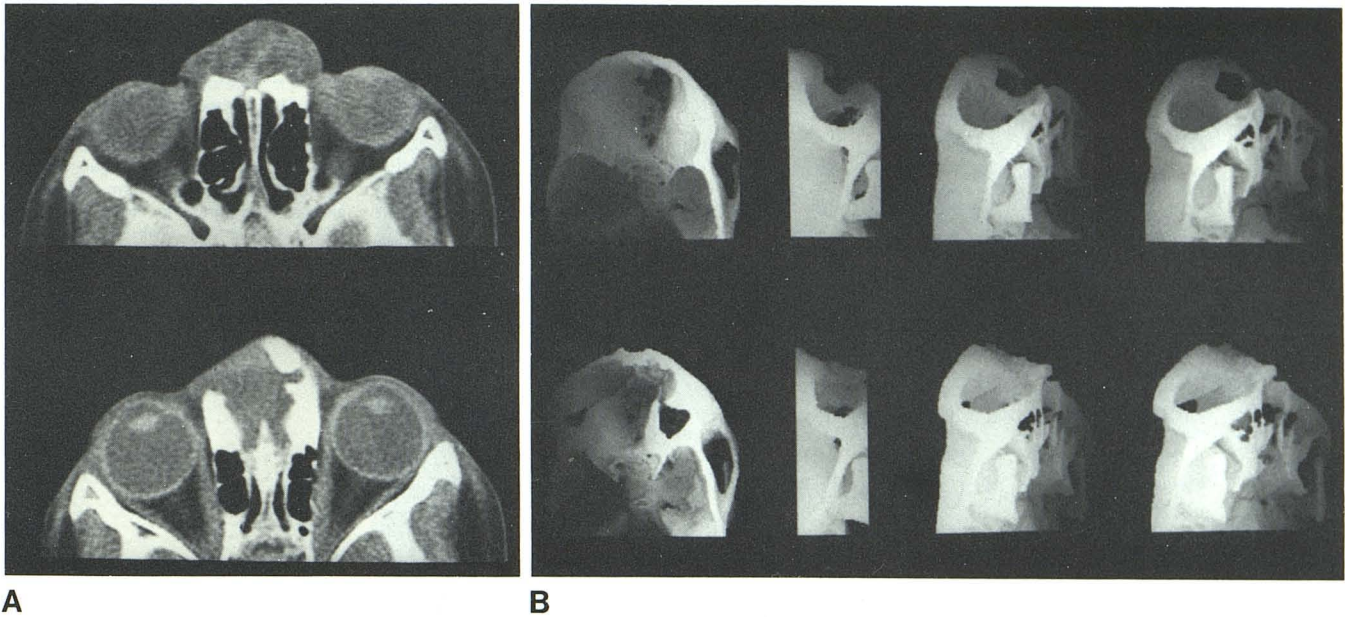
Case 5. Frontonasal encephalocele. A, Axial images of soft-tissue density extending below cribriform plate as well as anteriorly. B, 3-D CT reformation about X axis preoperatively (top) and postoperatively (bottom).
